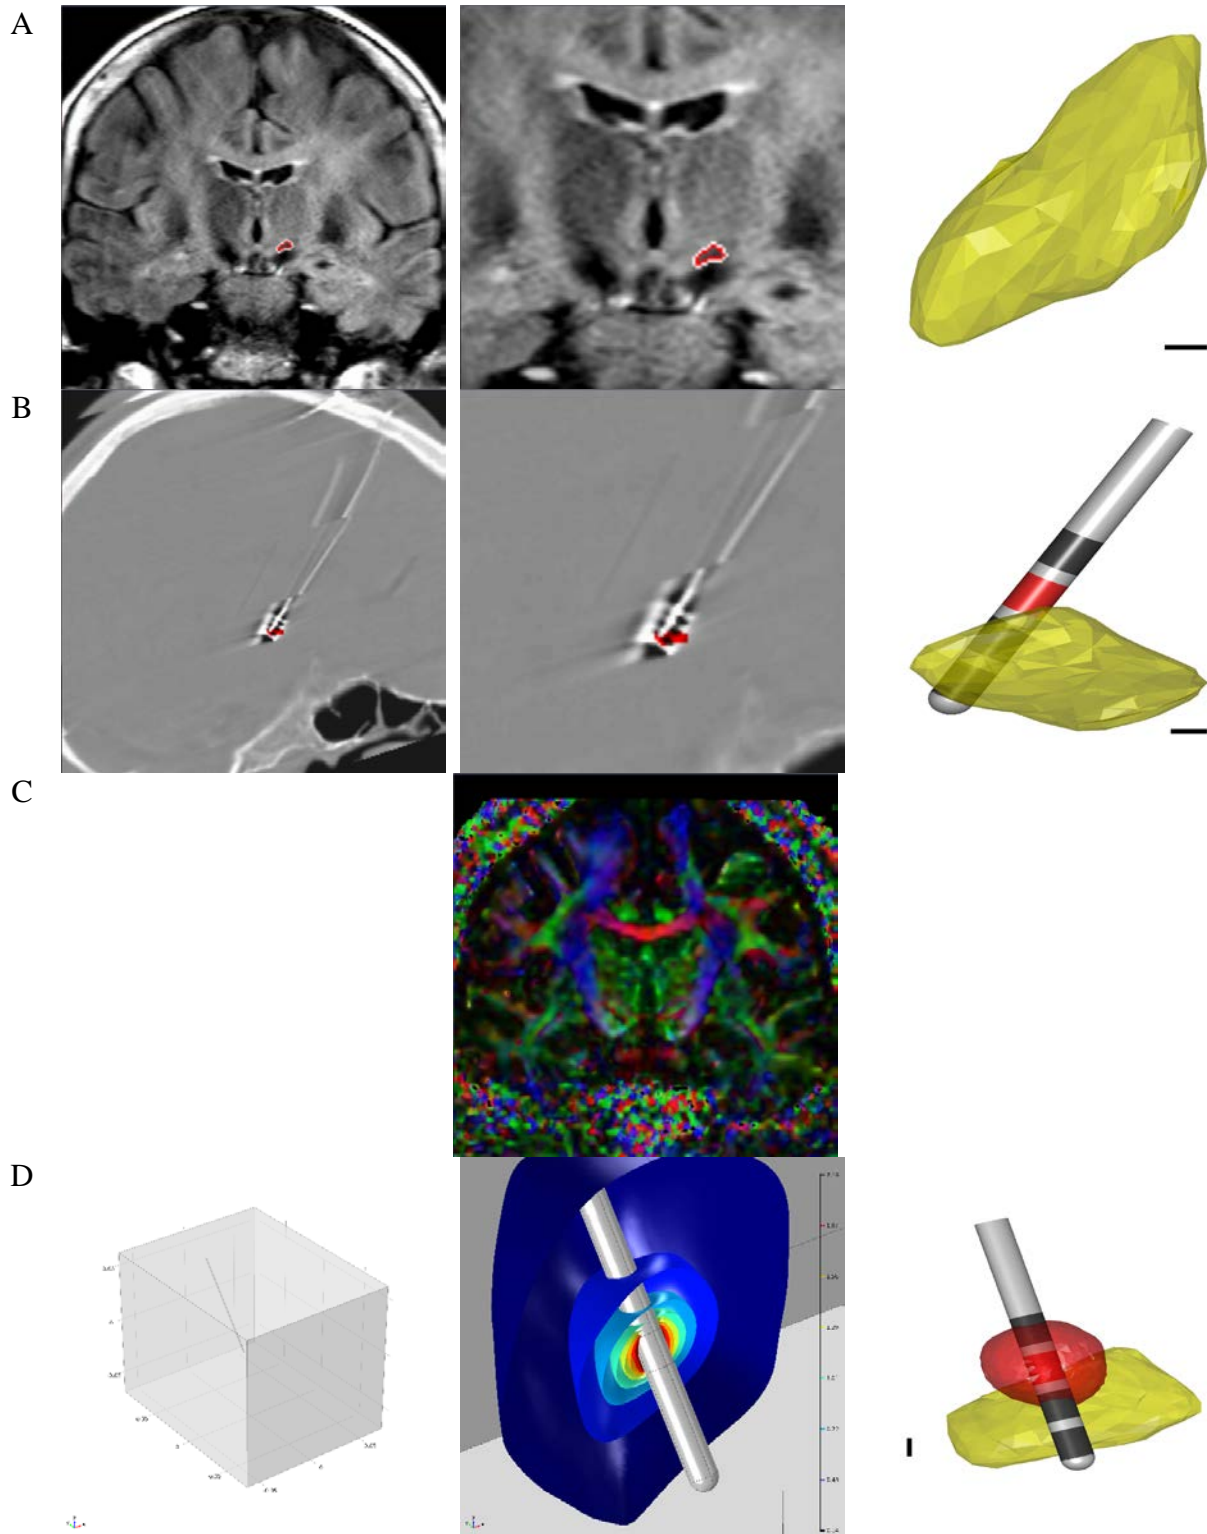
Atlas-independent, n-of-1 tissue activation modeling approach. (A) STN segmentation. Left: coronal MR image from one patient showing the left (outlined in red) and right STN. Center: zoomed in version. Right: left STN in MATLAB after STN segmentation. (B) Electrode contact localization. Left: sagittal CT image showing the electrode contacts (shown in black) of the left DBS lead. Left STN mask is shown in red. Center: zoomed in version. Right:
